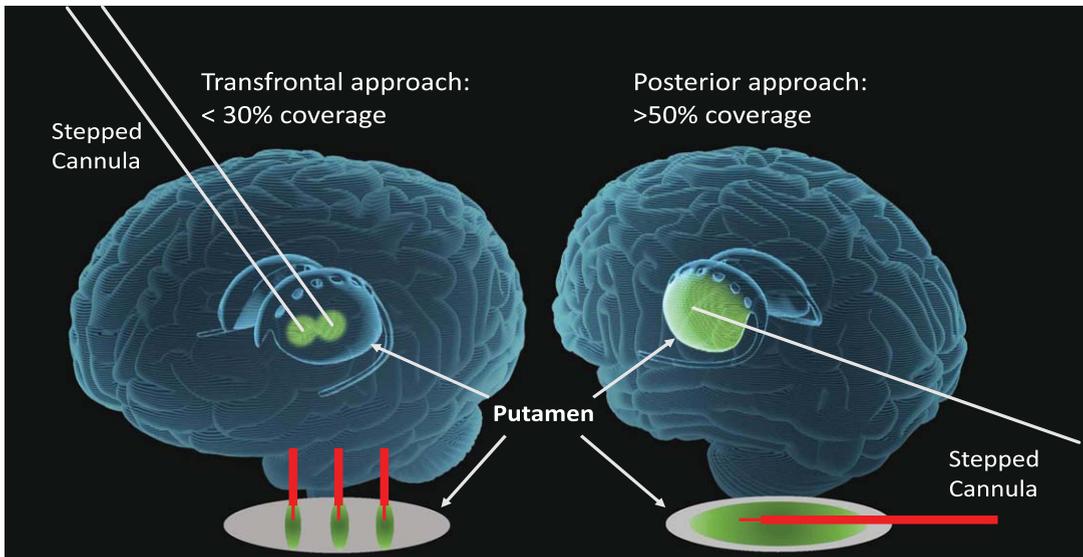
Transfrontal versus Posterior (occipital) trajectories utilizing CED. MRI-guided stereotactic approaches for vector delivery to the putamen utilizing convection enhanced delivery (CED) and stepped cannulae. This approach allows for precise targeting, shape-fitting infusions, and larger delivery volumes to improve the extent of transduced putaminal tissue, thereby increasing transgene production capacity. With the transfrontal approach, the cannulae are oriented to the short axis of the putamen limiting vector coverage to $< 30\%$, often requiring 2-3 tracts. The posterior (occipital) approach maximizes the delivery by paralleling the putaminal long-axis, requiring only 1 tract, which achieves $> 50\%$ putaminal vector coverage with larger infusion volumes.
